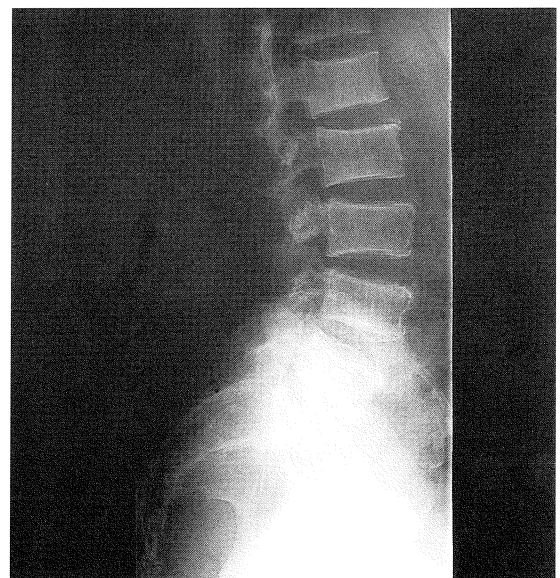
Radiograph of the lumbosacral spine (lateral)
